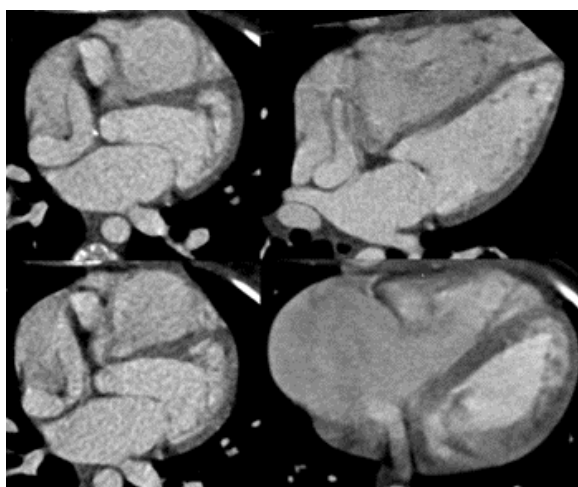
Chest CT scan showing fistulous tract between aorta and right atrium
